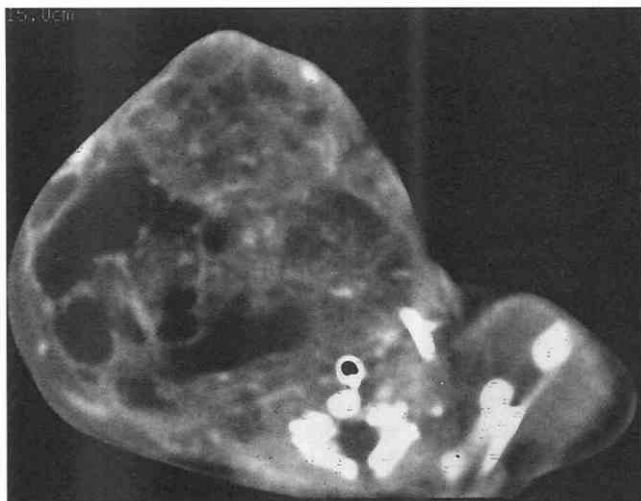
Cervical teratoma. Axial postcontrast CT scan. The majority of the anterior neck is involved with an extremely large, heterogeneous mass with mild enhancement. The vascular bundle on the right is not visualized secondary to tumor involvement. The infant required intubation because of mass effect on the airway.
